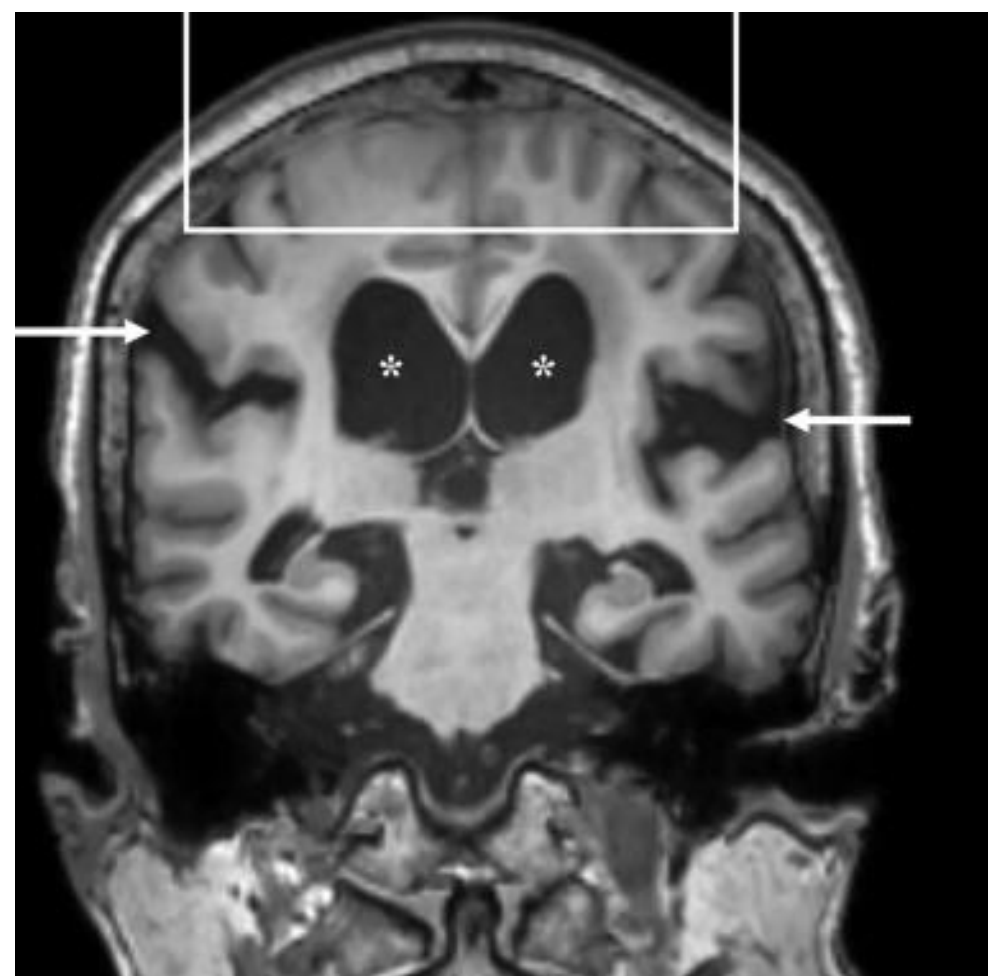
Representative coronal MRI demonstrating classic iNPH features, including ventriculomegaly and disproportionately enlarged subarachnoid-space hydrocephalus (DESH). Adapted from Park et al., 2021.
